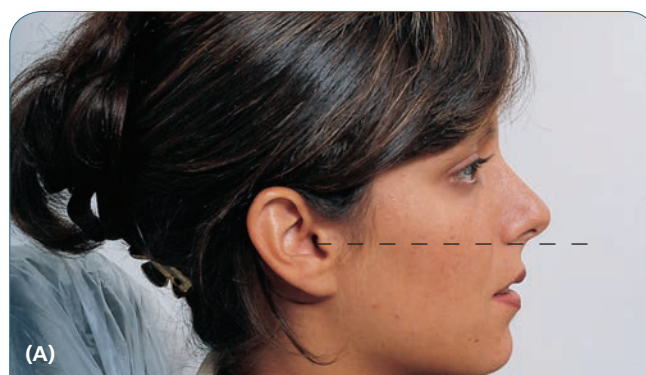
When exposing radiographs using the bisecting technique, the patient's head is positioned as shown for (A) the maxillary regions (tragus of the ear to the ala of the nose) and (B) the mandibular regions (tragus of the ear to corner of the mouth).
